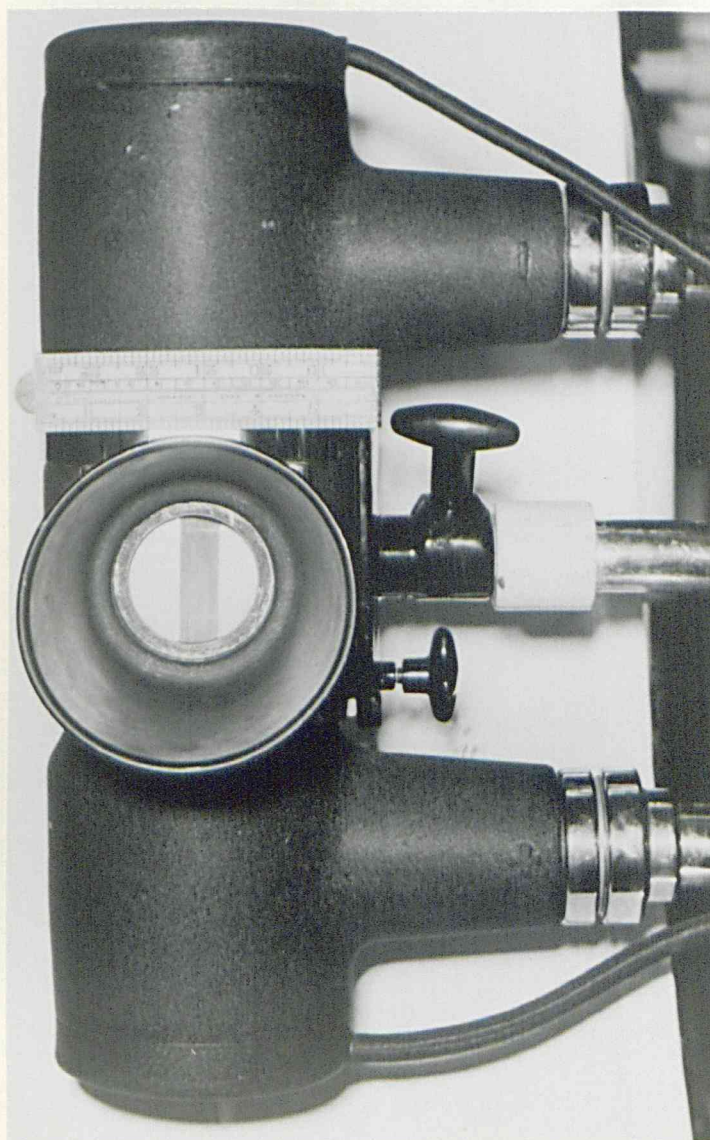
The present filter fitted in the casing of a Mullard R.A. x-ray tube. It is held in position by the cone.
